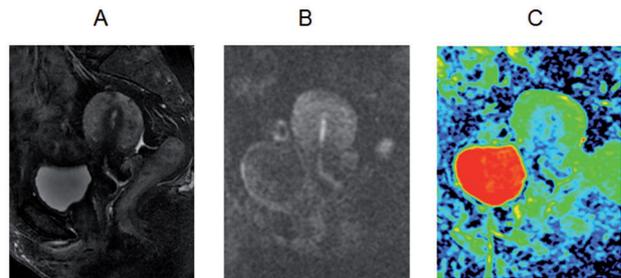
A 47-year-old pre-menopausal woman with normal endometrium and normal myometrium. (a) T2-weighted sagittal image shows high signal intensity in the endometrium and low signal intensity in the myometrium. (b) Sagittal DWI shows high signal intensity in the endometrium and low signal intensity in the myometrium. (c) ADC map image demonstrates the normal endometrium as a hyperintense area.
